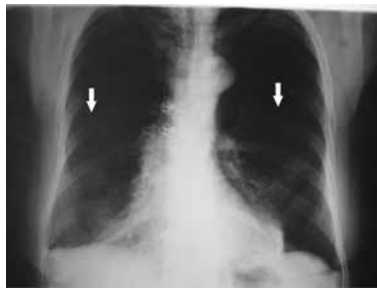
The initial chest X-ray showing bilateral pneumothorax.
